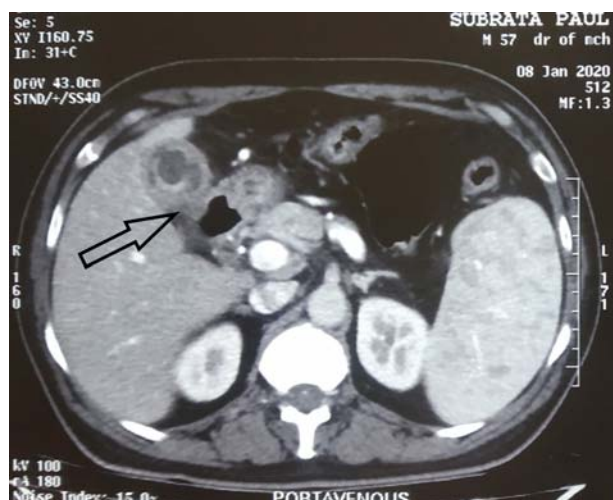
Showing finding of triphasic CT scan
